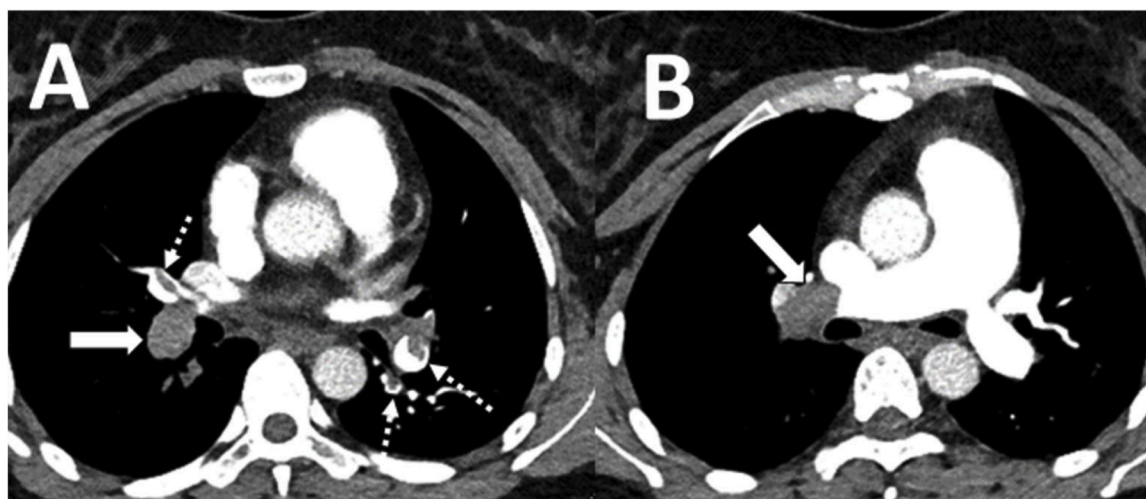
Axial CTPA demonstrations occlusive clot in the right main pulmonary artery (A and B: solid arrows) scored by two radiologists as weighting factor of 2 and partially occlusive clot in left basal segmental arteries (A: dashed arrows) scored by two radiologists as weighting factor of 1. CT obstruction index scored by two radiologists is 55%. (CTPA: Computed tomography pulmonary angiography).
